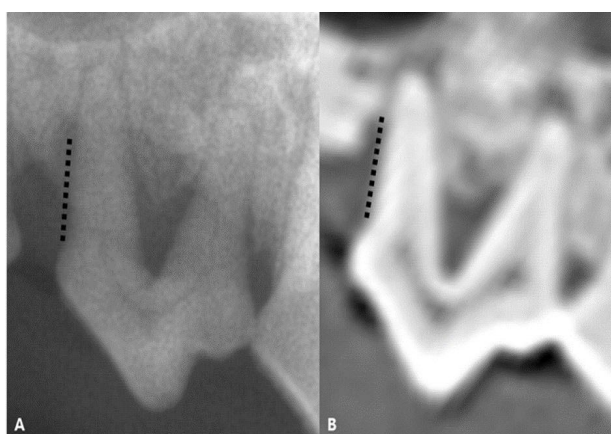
Image of the third premolar in a 4-year-old Beagle. Alveolar bone loss associated with periodontitis can be seen in both DTR (A) and CT 0.5 (B). The height of the bony defect (dotted line) was measured from CEJ to apex of the defect (unit of measure; mm).
